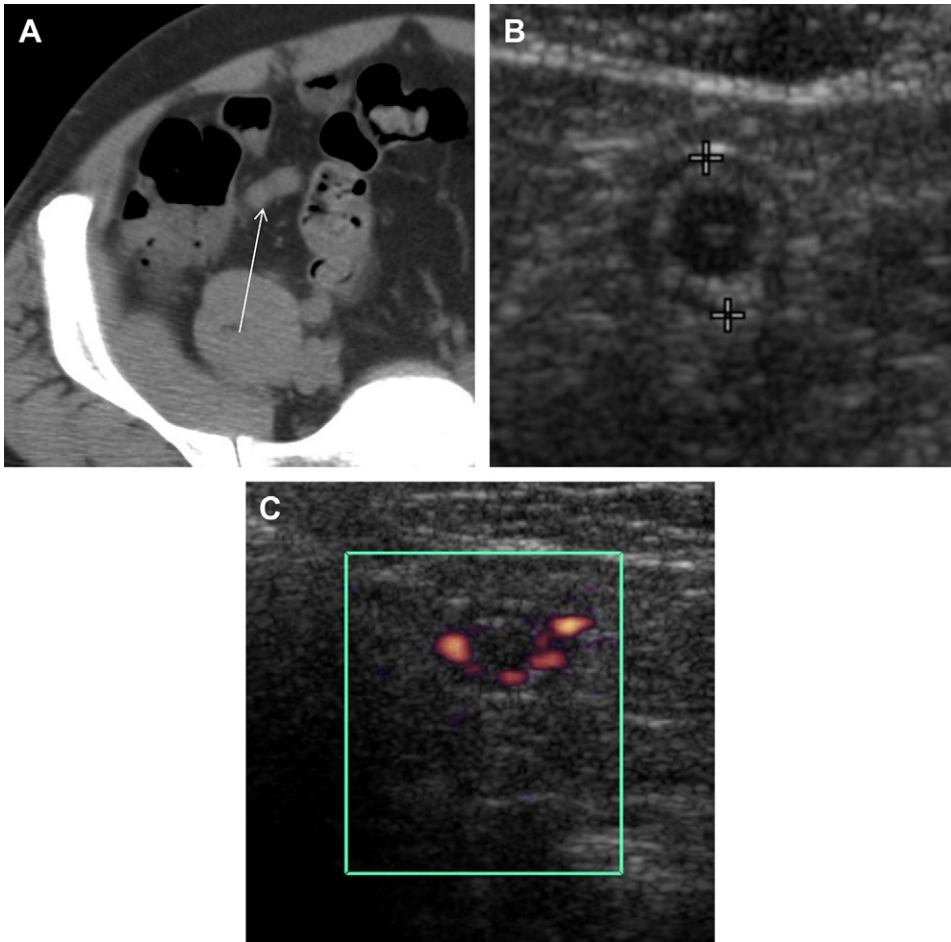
(A) Prominent appendix on CT with no periappendiceal inflammatory change (*arrow*). (B) Same appendix on US (*between calipers*), round in cross section, measuring 8 mm, and noncompressible. (C) Presence of Doppler signal further confirming appendicitis.
